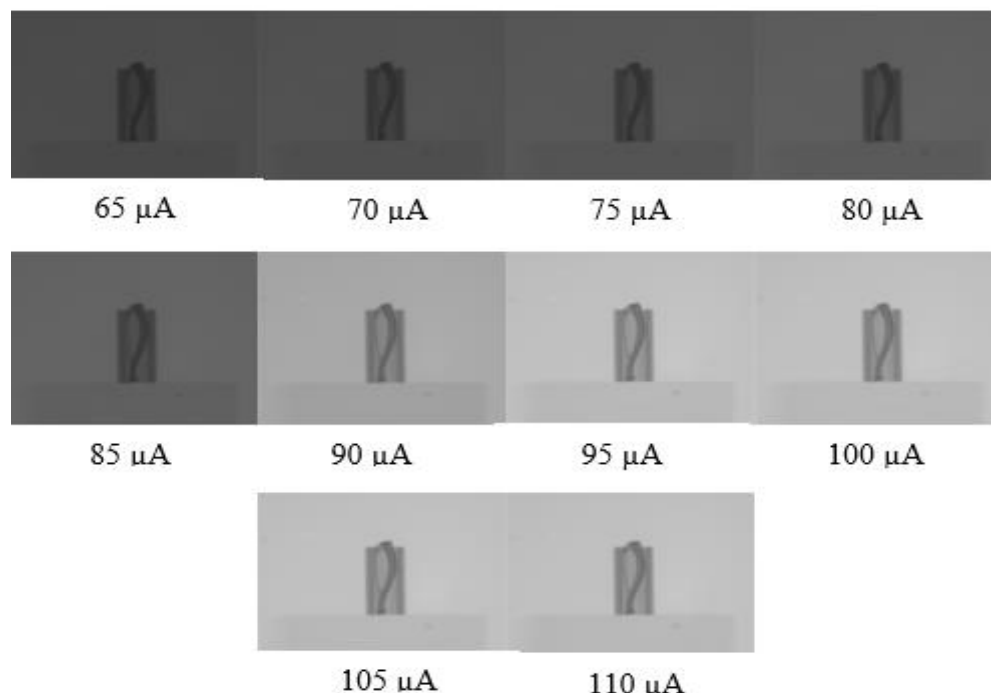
Typical radiographs that were acquired within the X-ray current range of 65 μA - 110 μA , X-ray tube voltage of 100 kV, FSD of 65 cm and X-ray exposure time of 1 sec.
